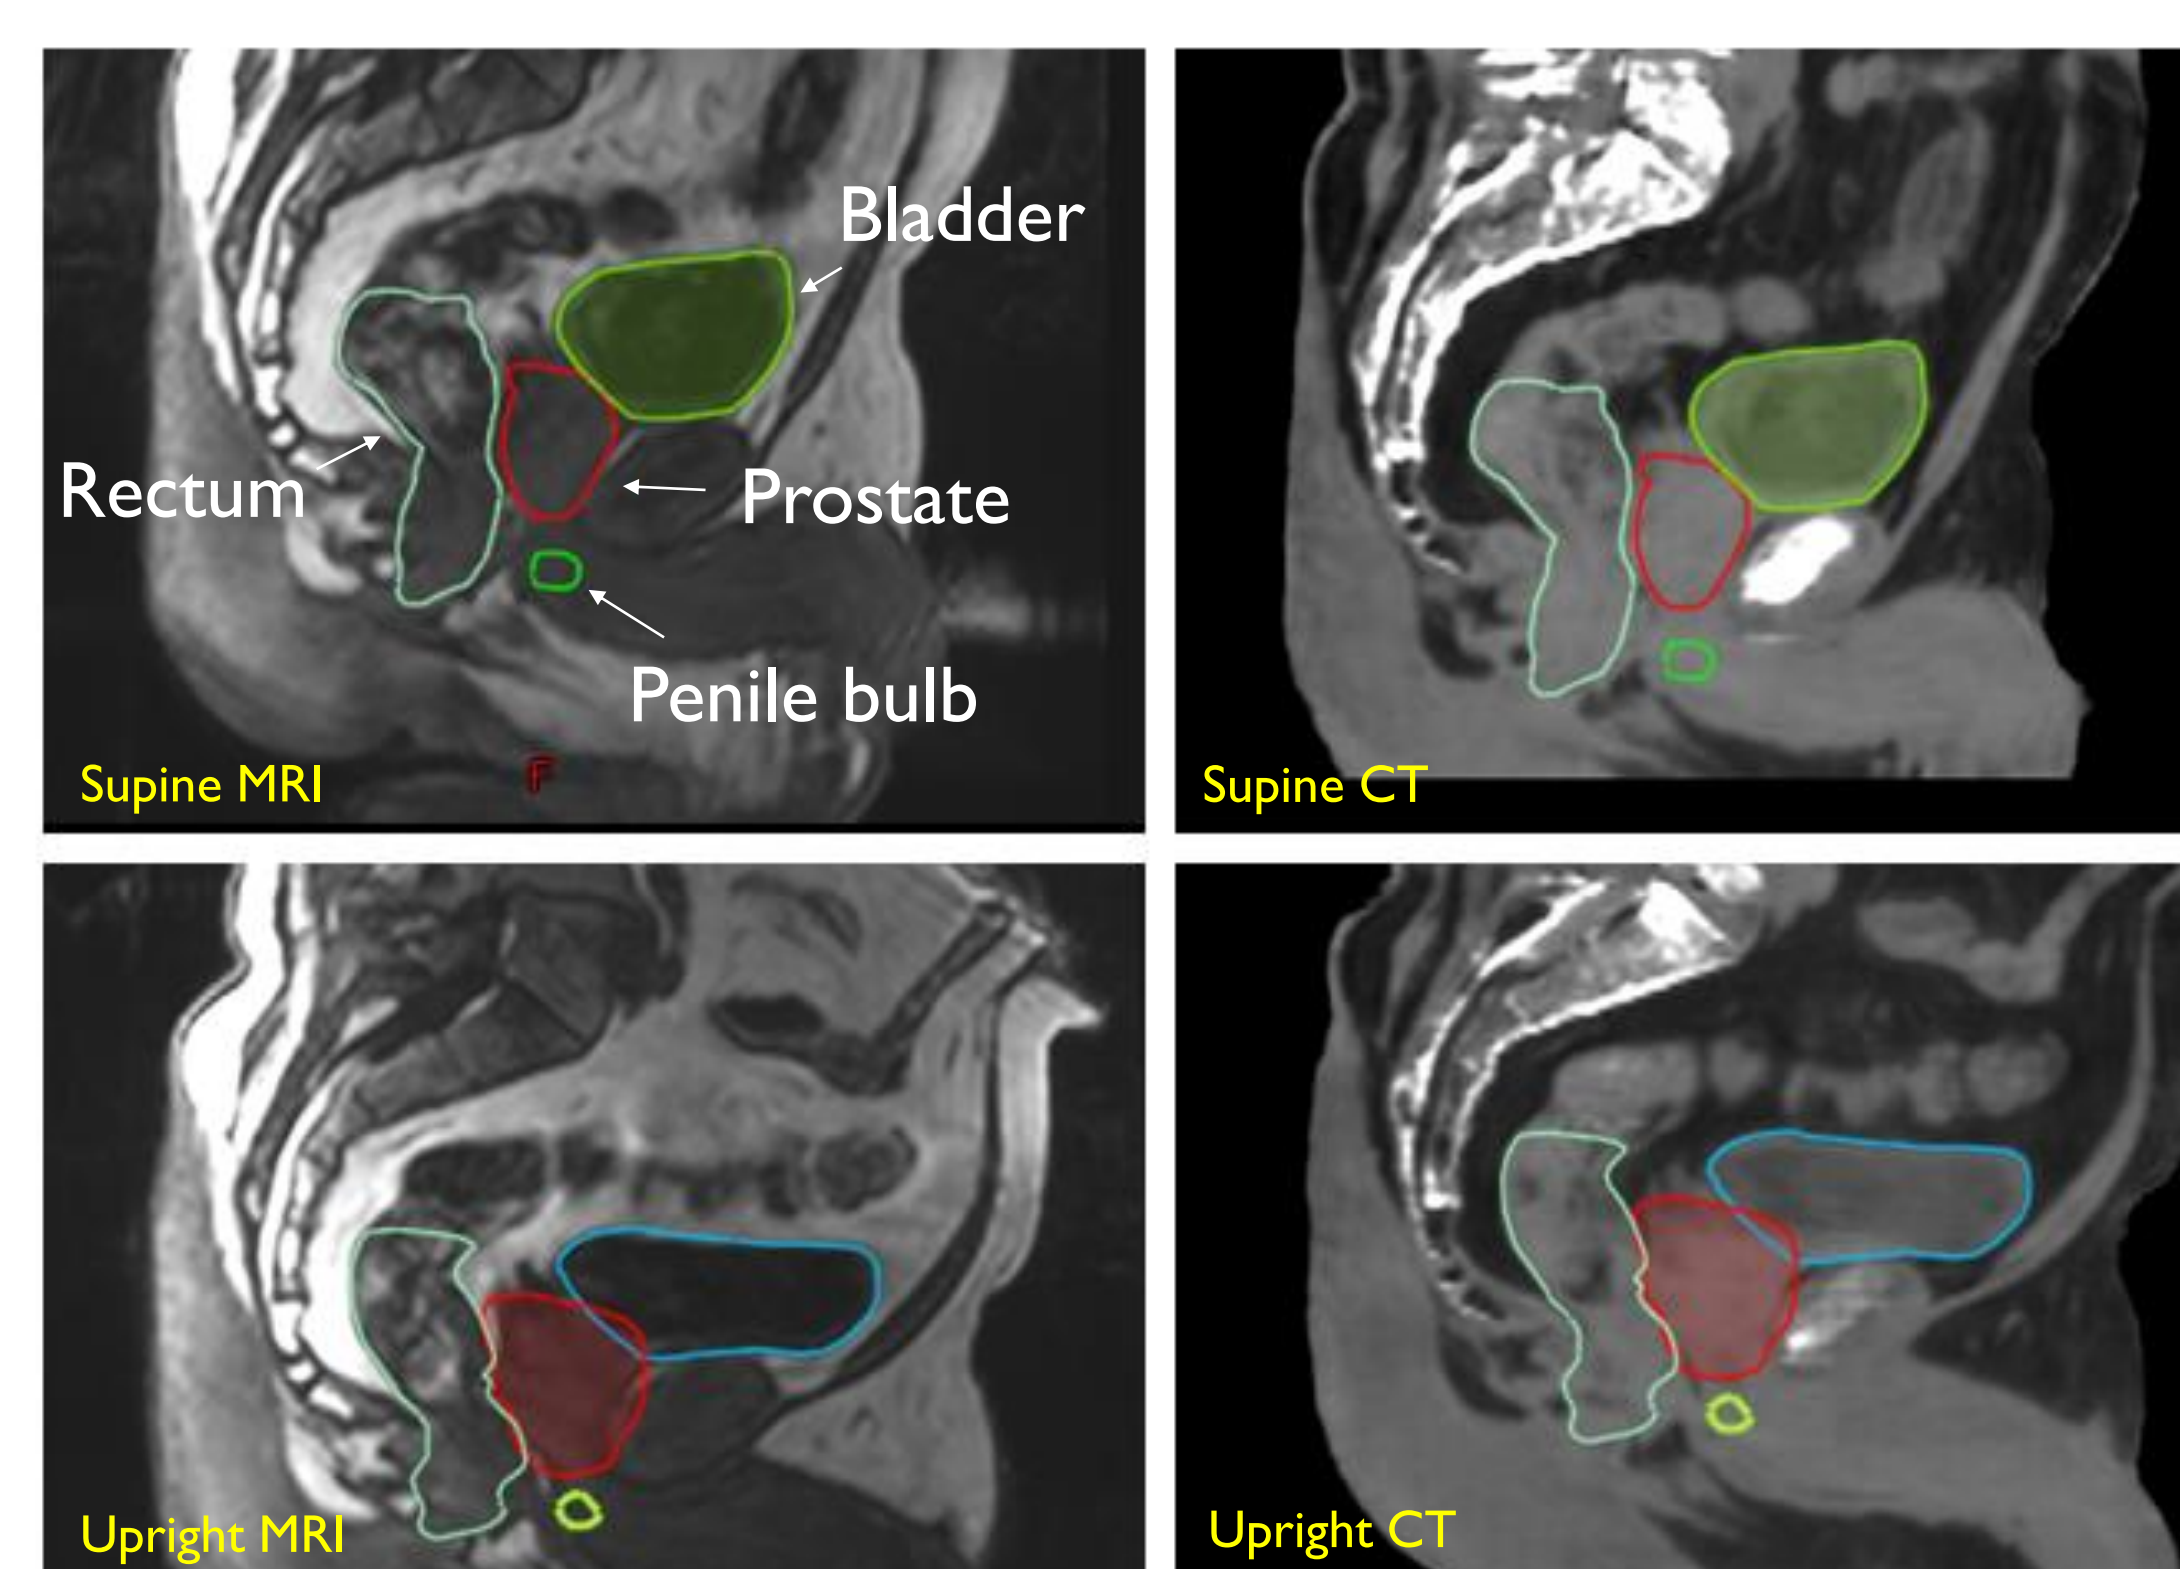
MRI scans acquired in upright and supine positions were converted to synthetic CTs for planning.
